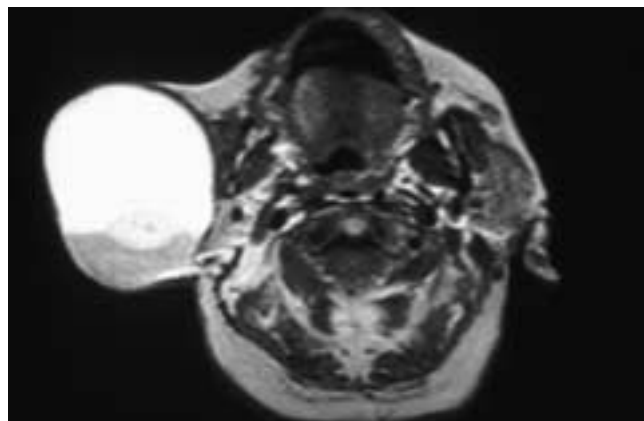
Axial T1-weighted MR image shows a large cyst in the right parotid gland. Hemorrhage is present in the upper portion of the cyst. This patient had an acquired hemorrhagic cyst. (Courtesy of Dr. Charles Schatz.)
